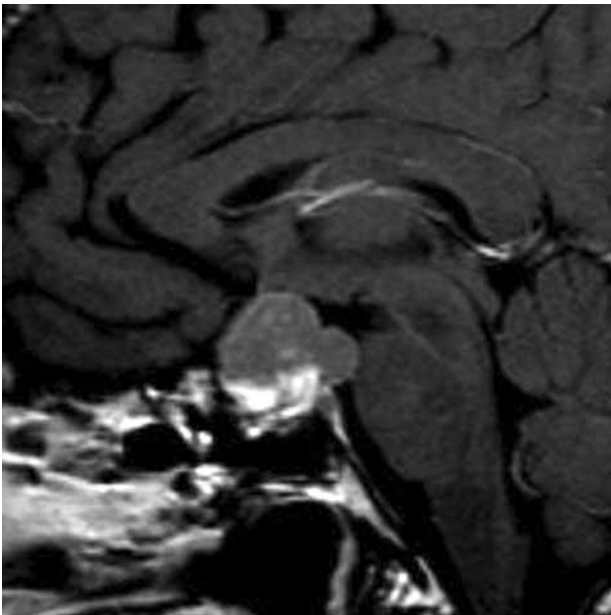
Magnetic resonance imaging (MRI) demonstrates a large suprasellar tumor. Sagittal view.
